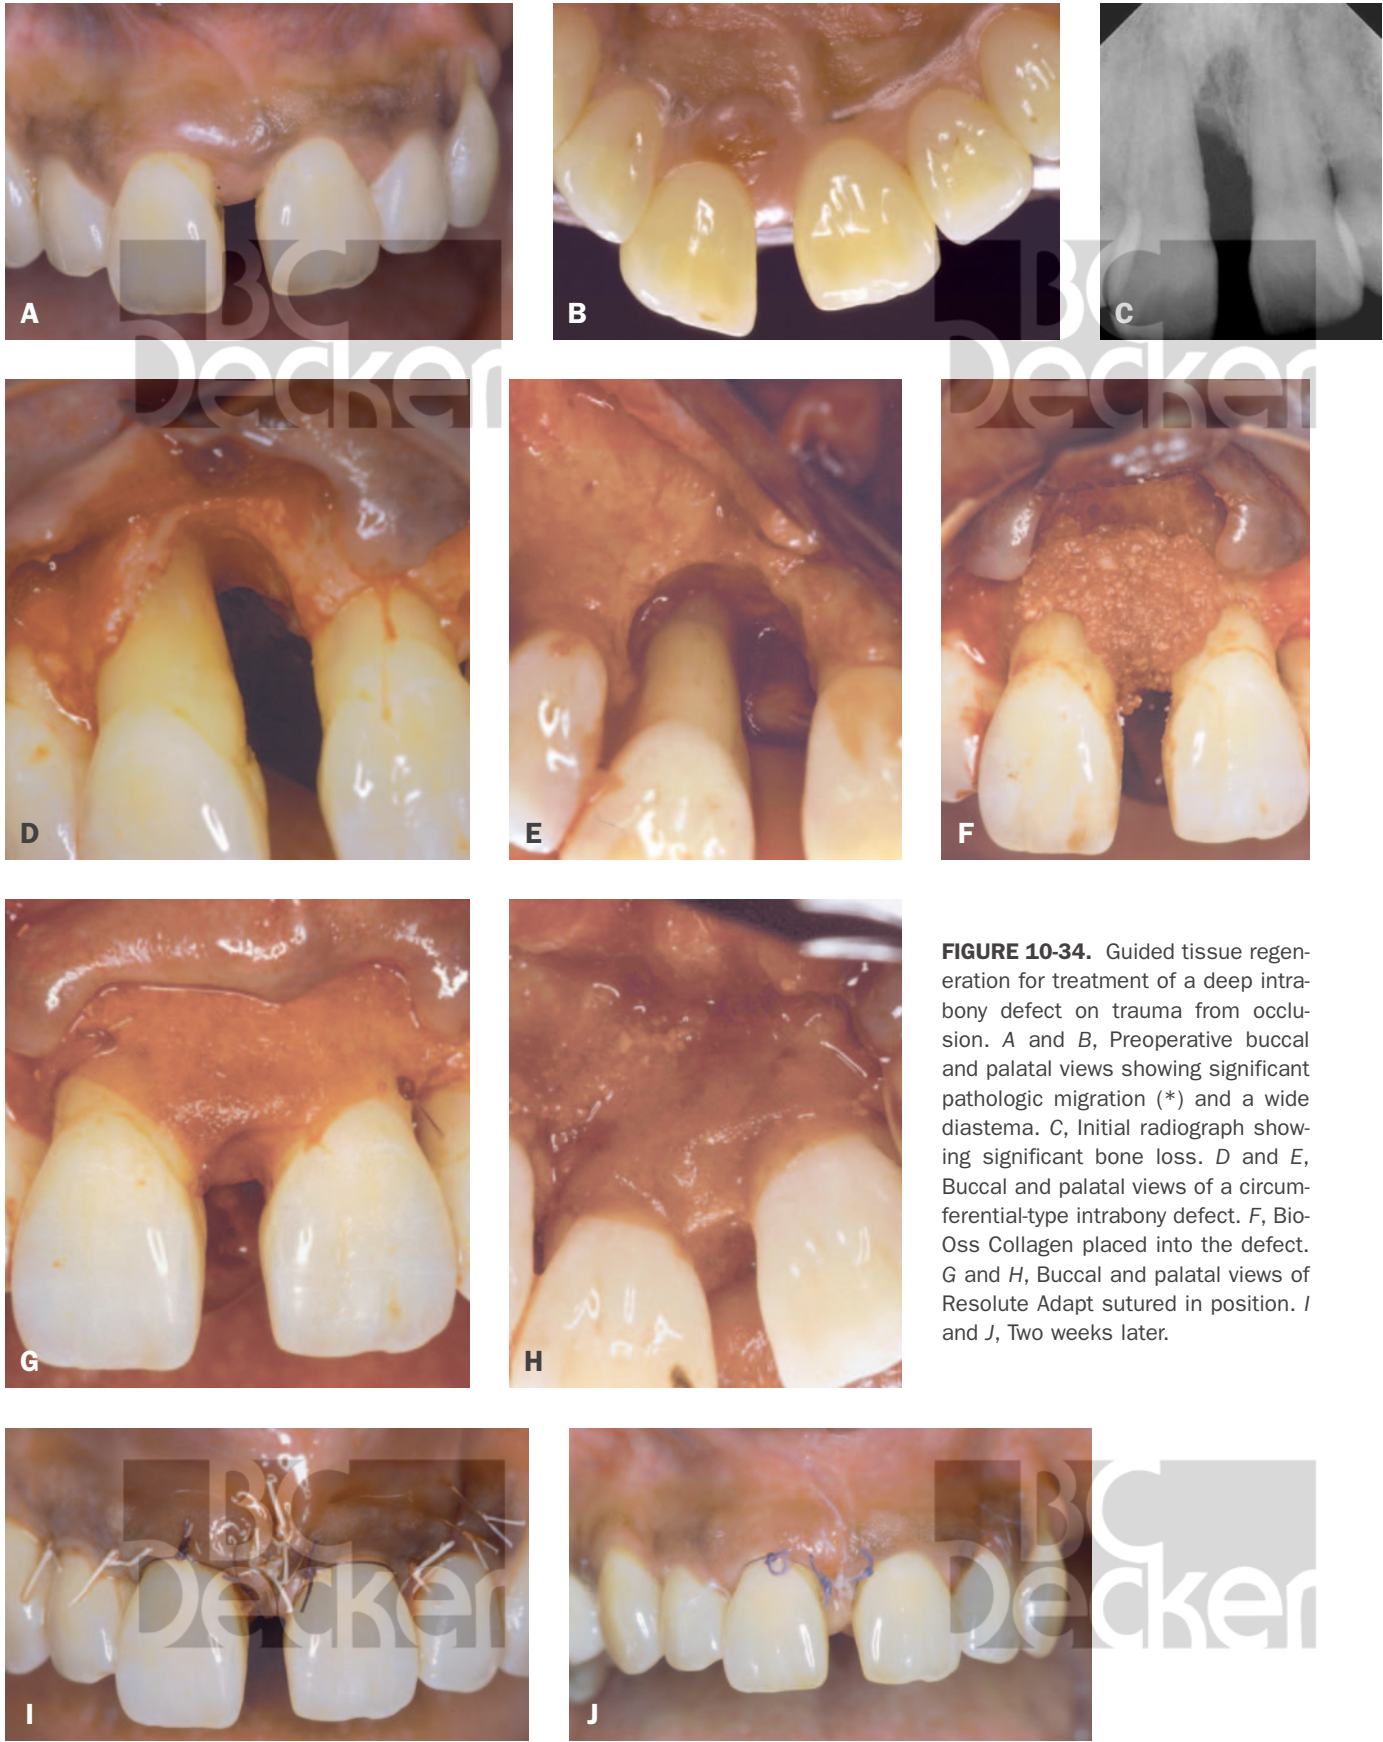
Guided tissue regeneration for treatment of a deep intrabony defect on trauma from occlusion. A and B, Preoperative buccal and palatal views showing significant pathologic migration (*) and a wide diastema. C, Initial radiograph showing significant bone loss. D and E, Buccal and palatal views of a circumferential-type intrabony defect. F, Bio-Oss Collagen placed into the defect. G and H, Buccal and palatal views of Resolute Adapt sutured in position. I and J, Two weeks later.
